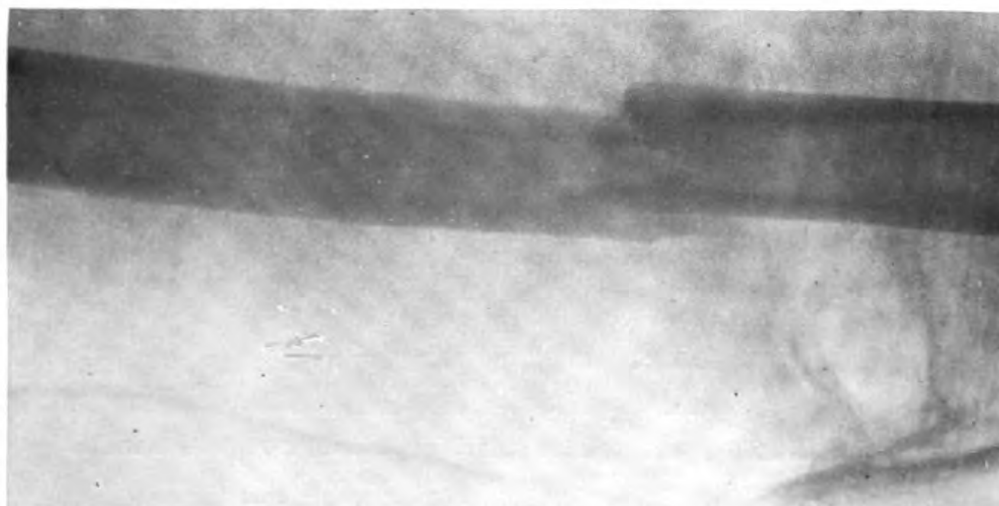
Case 4. Preoperative lateral x-ray.
